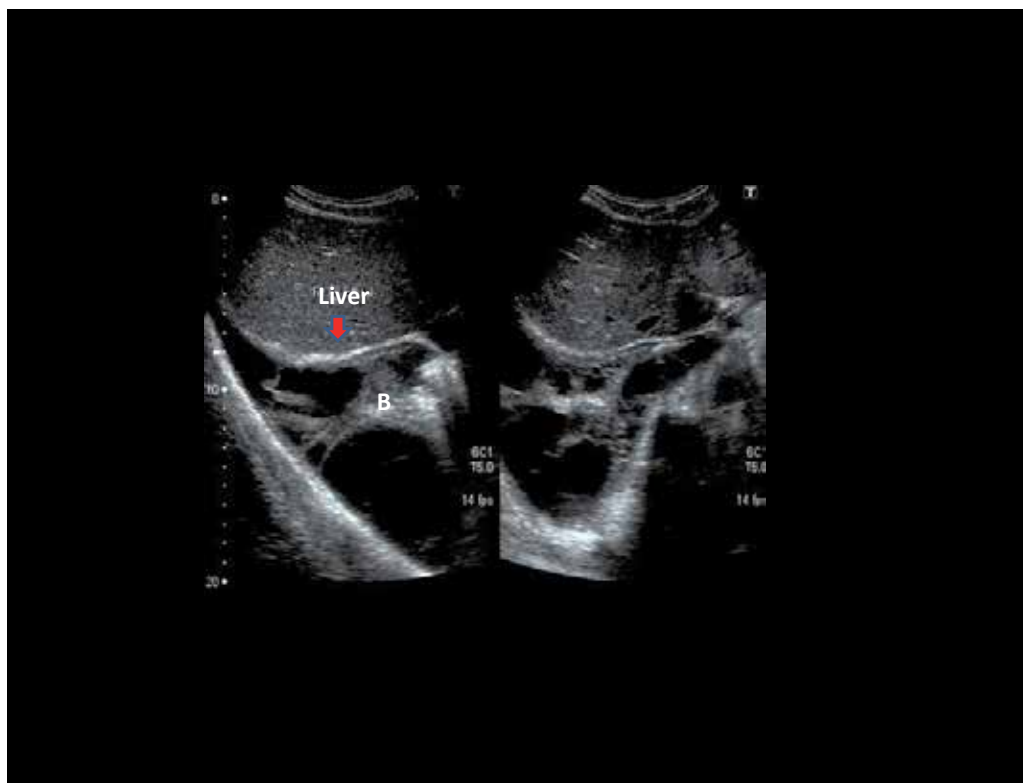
Attempted liver biopsy on a 36-year old female with non-specific hepatic dysfunction. The needle entered the pleural cavity. Ultrasound examination shows blood in the pleural sac (B) at various stages of organization. The diaphragm is marked by a red arrow.
